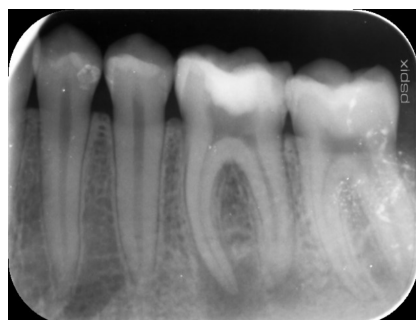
Preoperative radiograph of tooth 36 in conventional right angle exposure showing radiolucent areas around both root apices; no supposition of an additional canal in mesial root.
